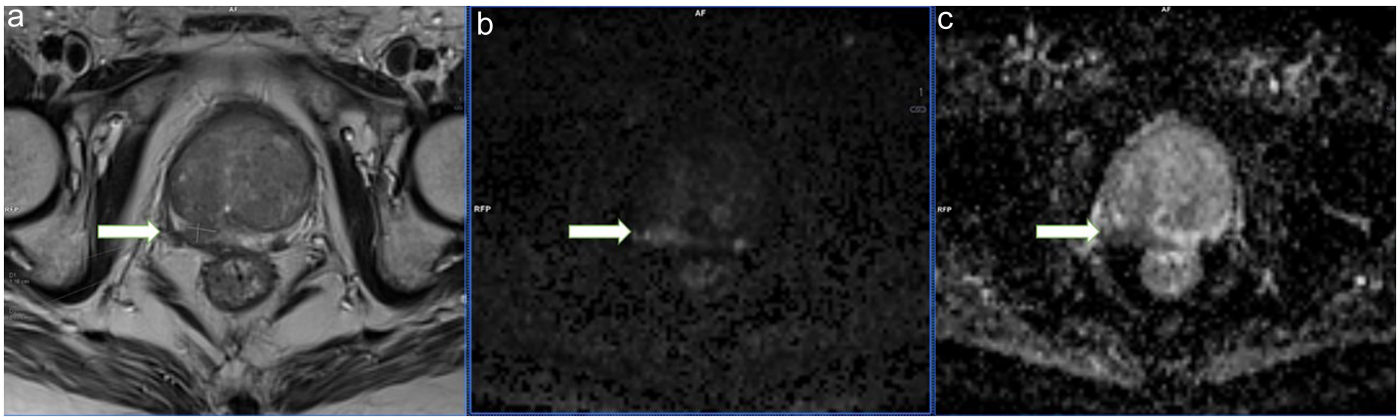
PIRADS 4 cases diagnosed with prostate adenocarcinoma. a) Axial T2W image shows hypointense nodular lesion in the right peripheral zone (white arrow). b) Calc. 1400 DWI, c) ADC map shows diffusion restriction of the lesion (white arrow).
